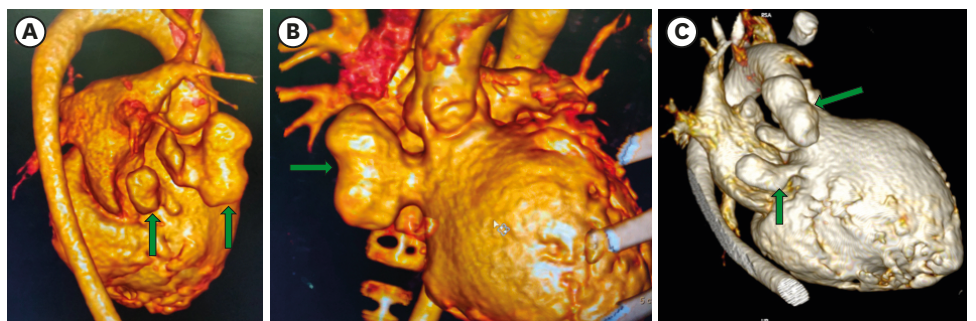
Three dimensional reconstruction of computed tomographic cardiac angiogram showing multiple sub annular aneurysm in different views (green arrow).
